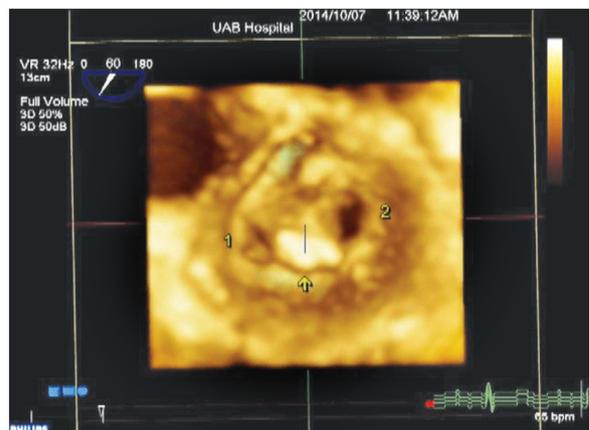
Live/real time three-dimensional transesophageal echocardiography. Arrow points to MitraClip. #1 and #2 represent the two mitral orifices resulting from MitraClip device placement.
